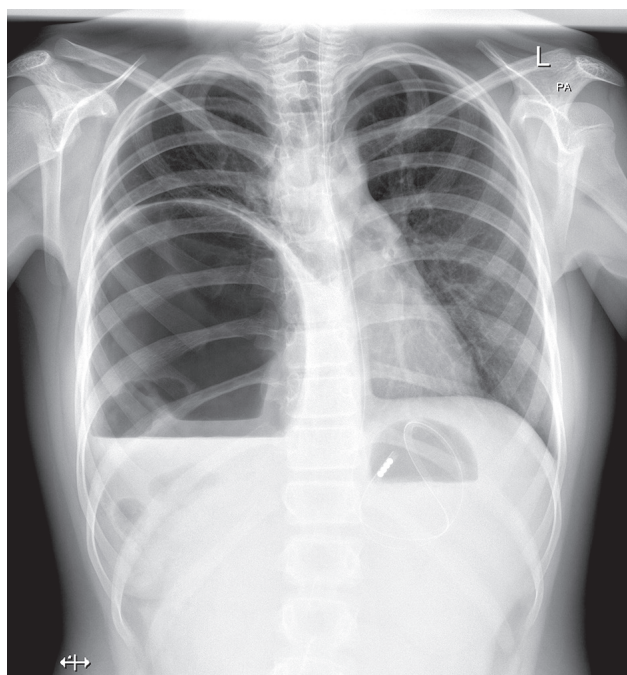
Preoperative chest X-ray with nasogastric tube
